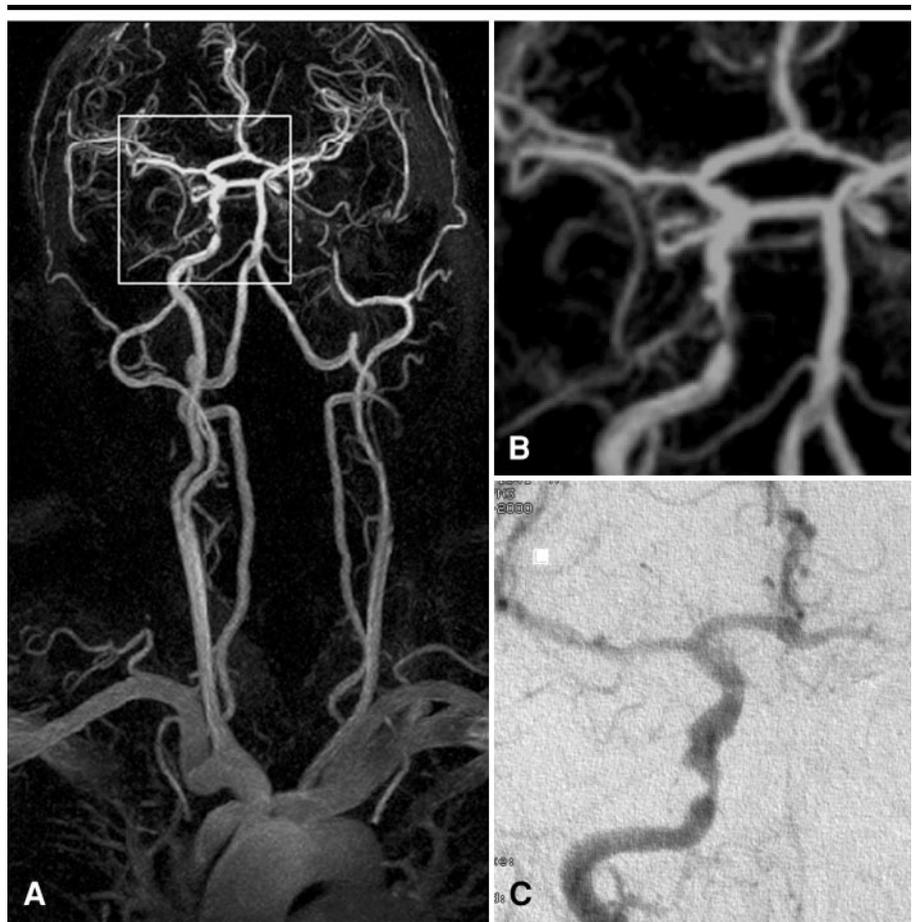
MIPs from gadolinium-enhanced 3D gradient-echo MR angiography with CENTRA in a single patient. (A) Coronal view shows occlusion of the left ICA and severe stenosis (grade III) of the right ICA (box). (B) Enlarged ($\times 3$) MIP of the petrous segment of the right ICA shows a severe stenosis that was confirmed at (C) conventional x-ray angiography.
